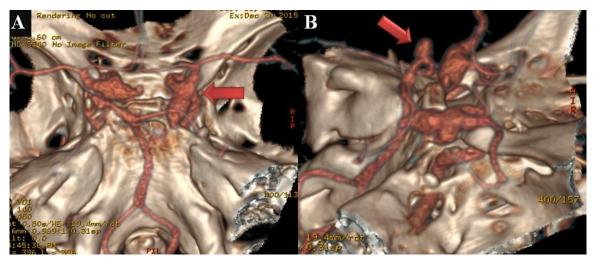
CT angiography with 3-dimensional reconstruction of the intracranial vessels showing dysplasia with right posterior communicating artery aneurysm (red arrow) (A). P1-P2 junction aneurysm (left posterior cerebral artery) (red arrow) (B) (from *Turliuc et al.*, 2017b)
